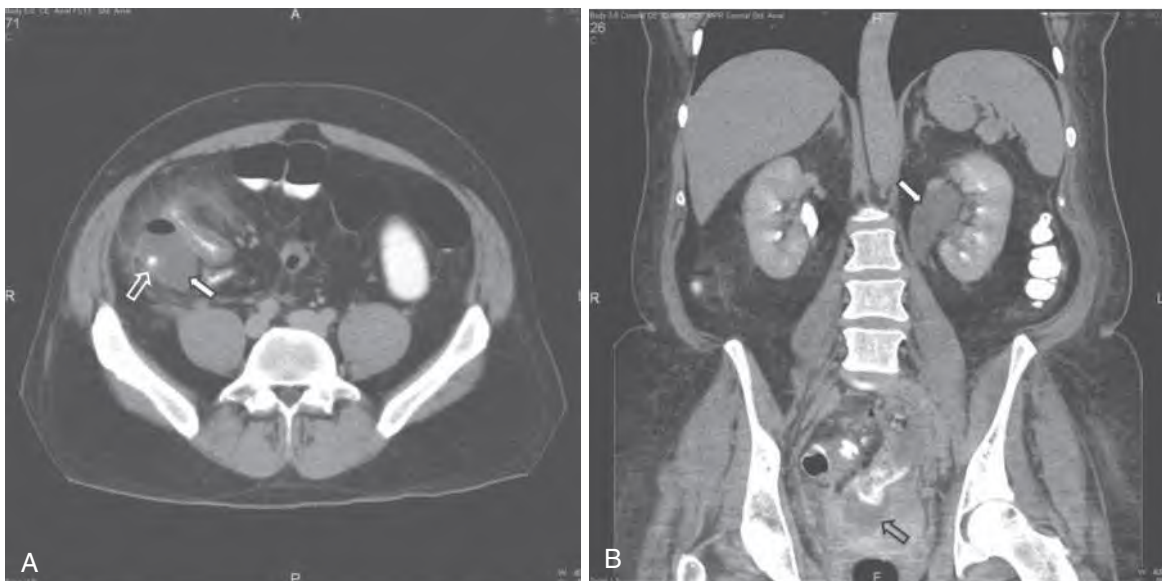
Computed tomographic scans of abdomen and pelvis after administration of oral and intravenous contrast medium. (A) Perforated appendicitis: right lower quadrant collection with an air-fluid level (solid arrow) surrounding a dilated appendix (open arrow). (B) Perforated diverticulitis associated with abscess (open arrow), producing obstructive hydronephrosis (solid arrow).
